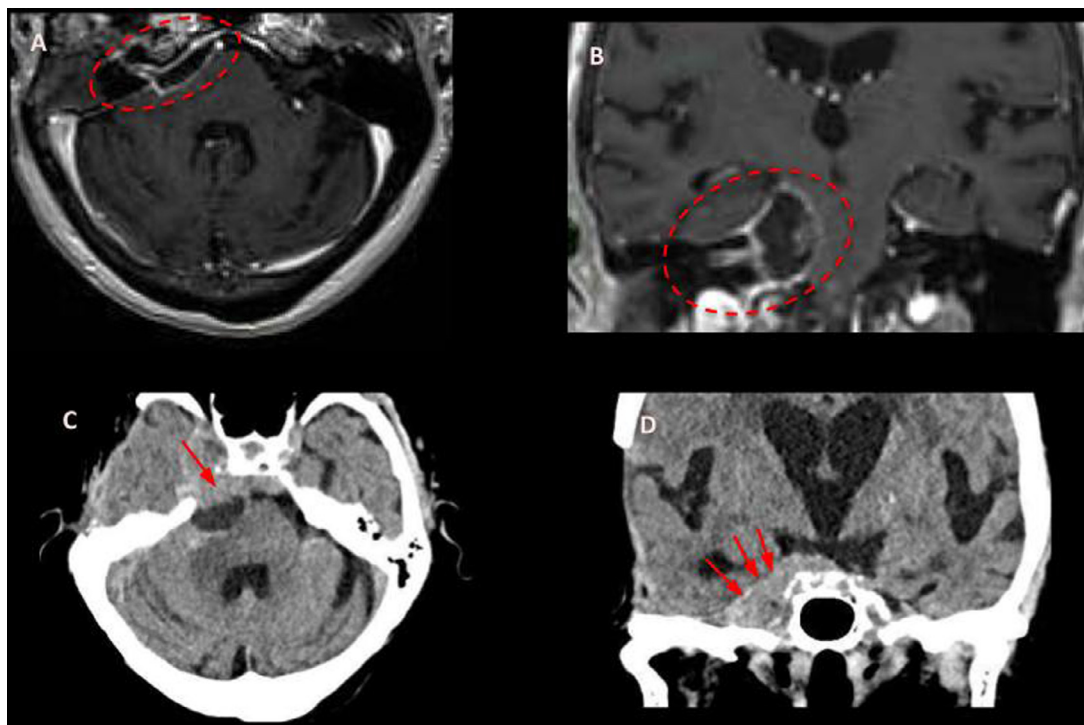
The axial (A) and coronal (B) T1-weighted post-contrast images show a large SCC residual in the right CPA after partial resection (red circles). The axial (C) and coronal (D) CT scan images with contrast show marked tumor progression with bone lysis (C, red arrow) of the petro-clival junction. This invades the cavernous sinus (D, red arrows).
